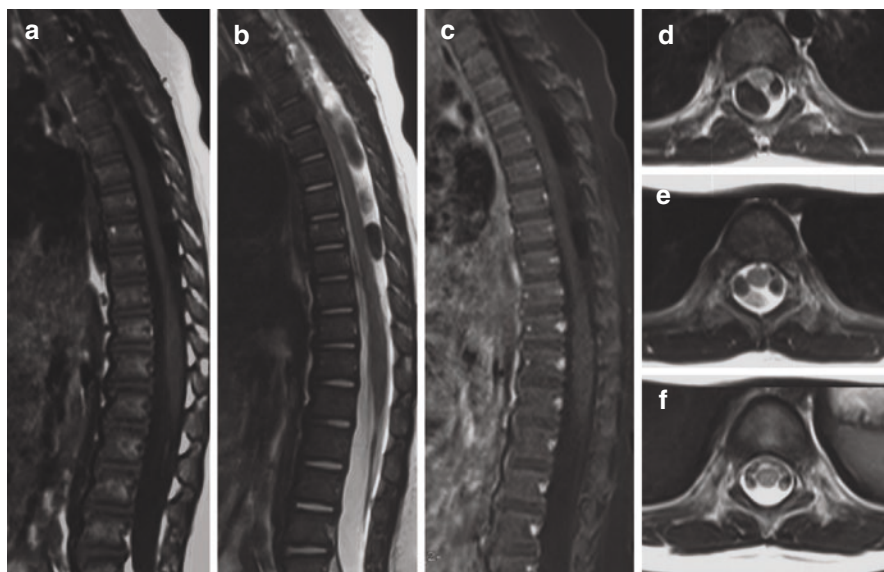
Tethered cord syndrome with CSF artifacts (17-month-old boy). Enhanced MRI and intra-operative exploration verified that they were artifacts. (a) T1 WI. (b) T2 WI. (c) Enhanced T1 WI. (d–f) Axial view of different layers on T2 WI. CSF cerebral spinal fluid, WI weighted image
